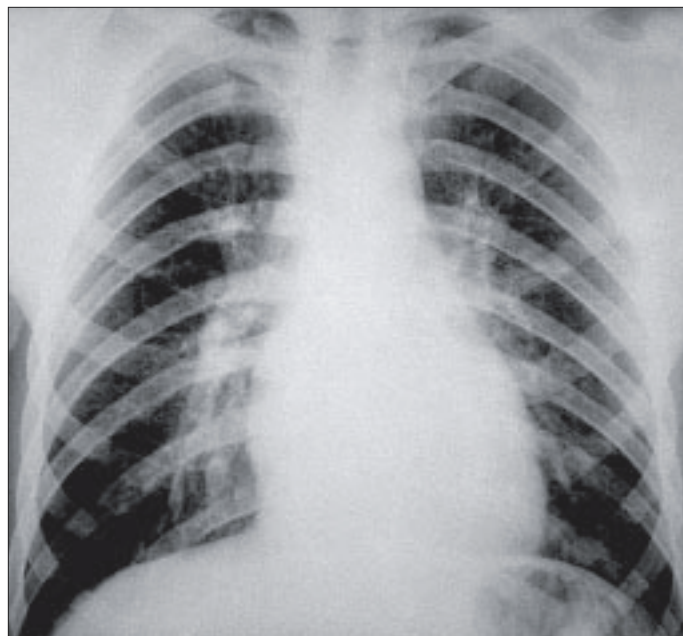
Chest radiograph at the first hospitalization in October 1960.
